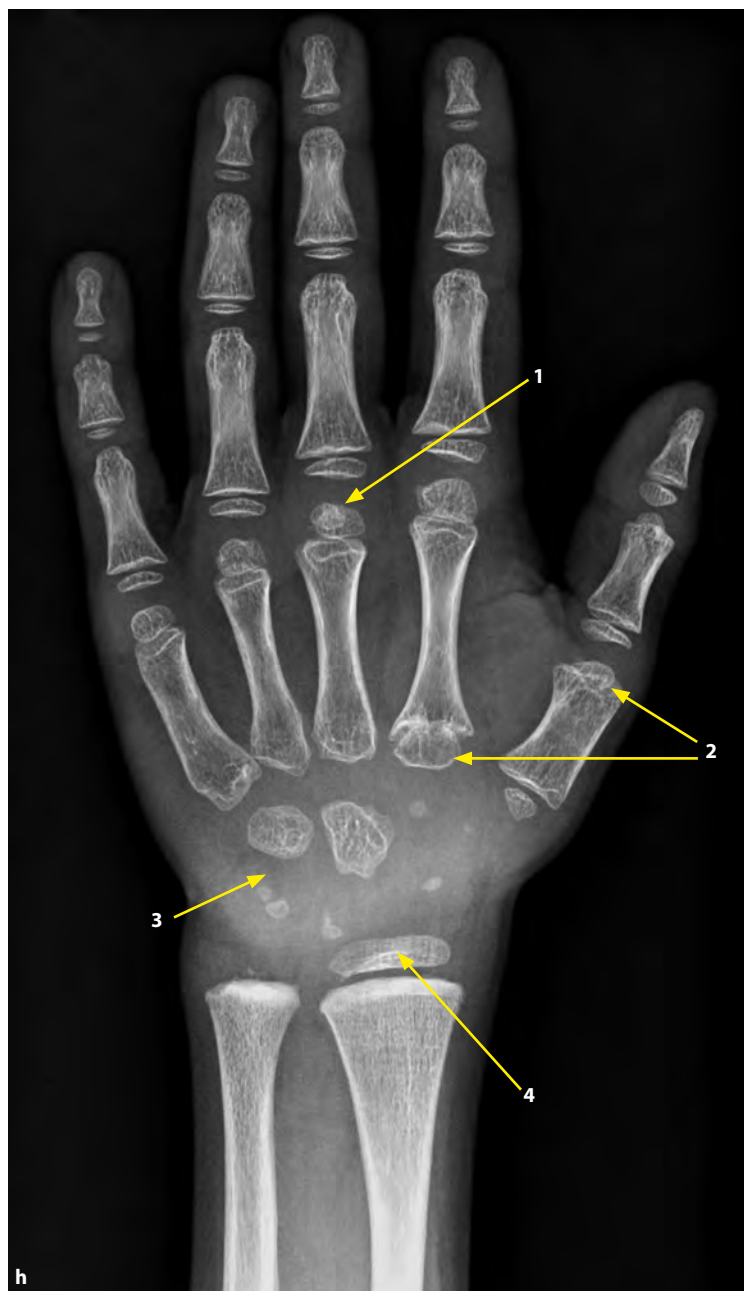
a–h. Case 2, 8.2 years old boy: e–h. X-rays of hips and pelvis, spine in lateral projection, knees and tibias and left hand in AP projection and at the age of 7.5 years showed. e. small flat epiphyses of femoral heads, small ossification centres of great trochanters. f. accentuated lumbosacral lordosis, platyspondyly in the thoracic and lumbar region. g. valgus knees, small, flattened epiphyses of distal femur, proximal tibia, and fibula bilaterally (see arrows), widened and thickened metaphyseal margins of distal femur and proximal tibia bilaterally (see arrows) and vertical bands of thickened bone structure in metaphyses. h. pseudoepiphysis of the 1st and 2nd metacarpal (see arrows – 2), double ossification centres of the head of the 2nd–5th metacarpal (see arrows – 1).
